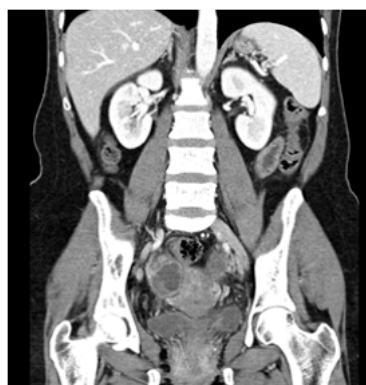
Abdominal CT scan - organized and heterogeneous peritoneal fluid in the pelvic cavity and a thickened appendix (14 mm) associated with fluid collection..
